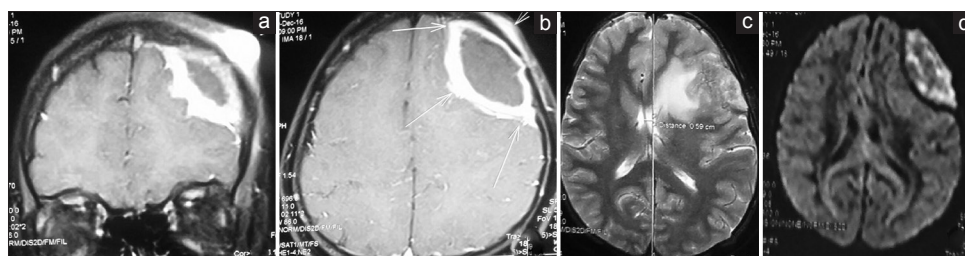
Contrast enhanced MRI. (a) Coronal cuts showing enhancement of the extradural collection and soft tissue in the scalp. (b) Axial images showing the dural enhancement. (c) T2 weighted images showing oedema of left frontal cortex. (d) Diffusion restriction is seen
